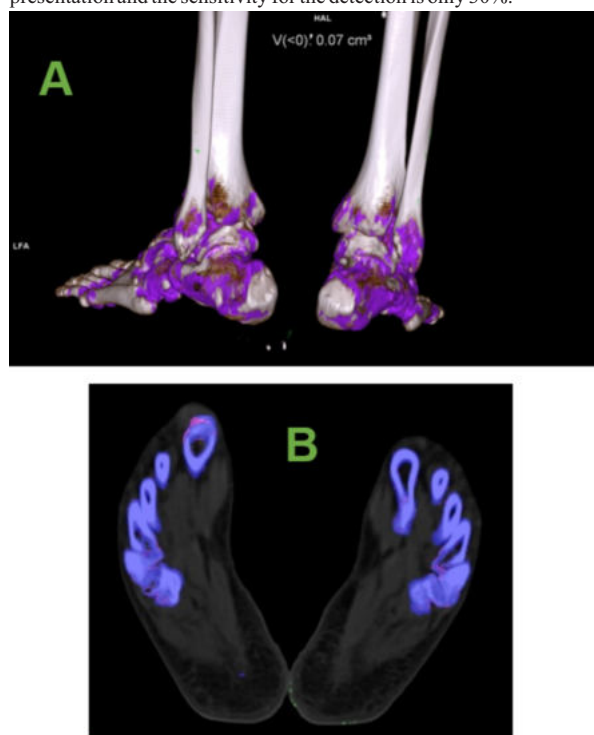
Skin artifact on dual energy CT (DECT) images of patient with suspected gout.
